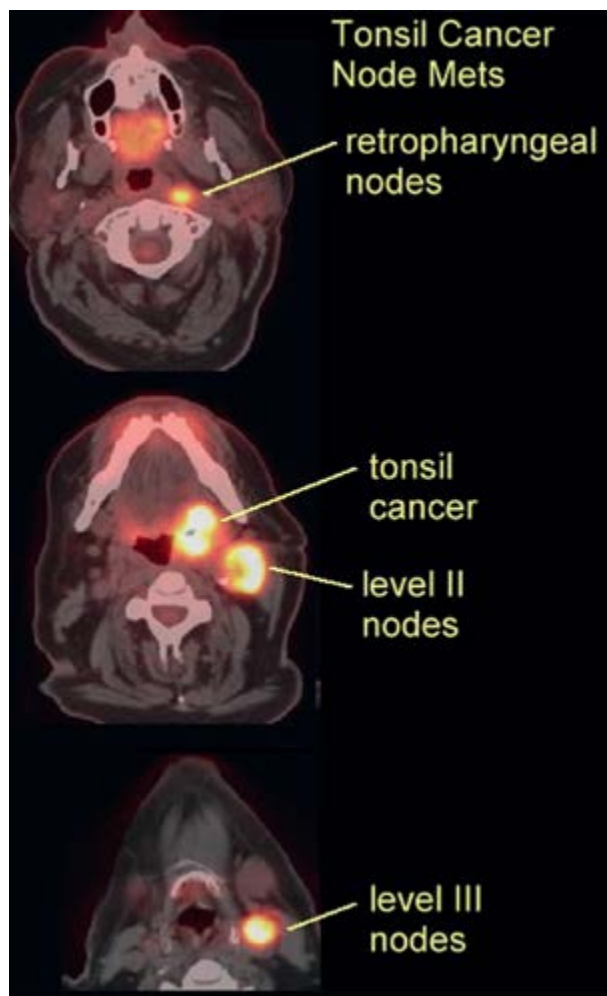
PET-CT scan in axial view demonstrating asymmetrical contrast medium enhancement of the left tonsil with associated uptake in ipsilateral lymph nodes.
